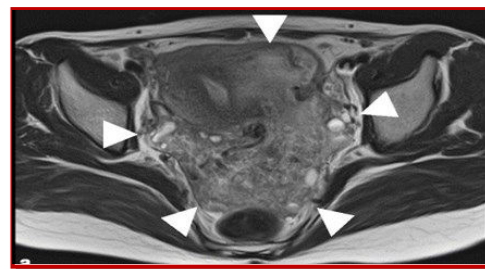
Magnetic resonance imaging shows a pelvic mass, located in the left posterolateral myometrial wall, with extrauterine extension to the pelvic cavity
